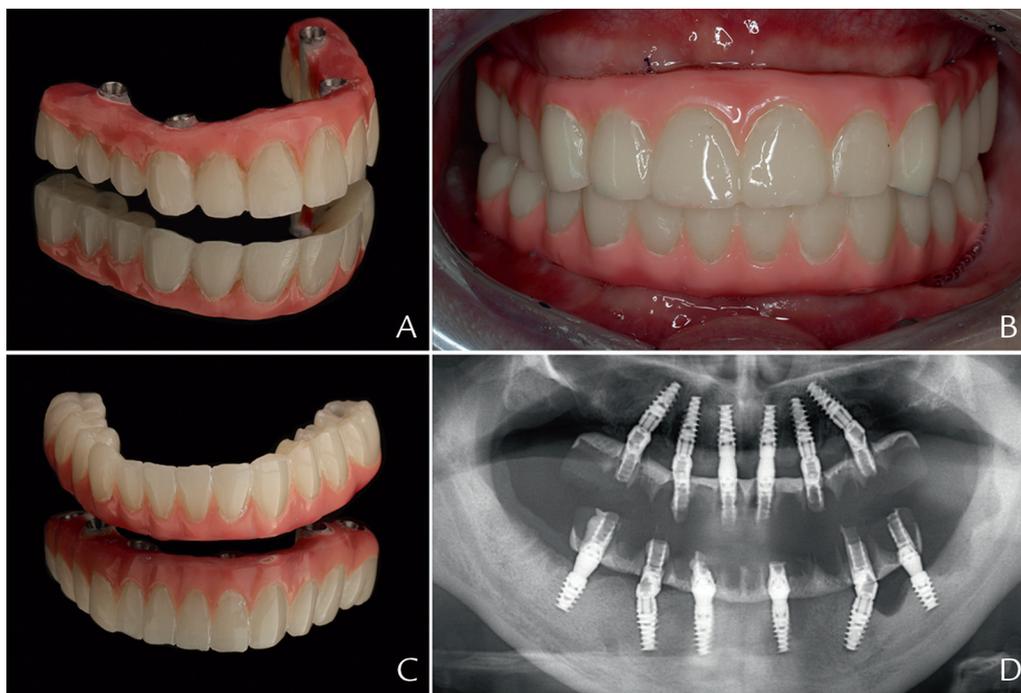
A, Maxillary complete-arch interim restoration. B, Intraoral view. C, Mandibular complete-arch interim restoration. D, Panoramic radiograph after delivery of restorations.
